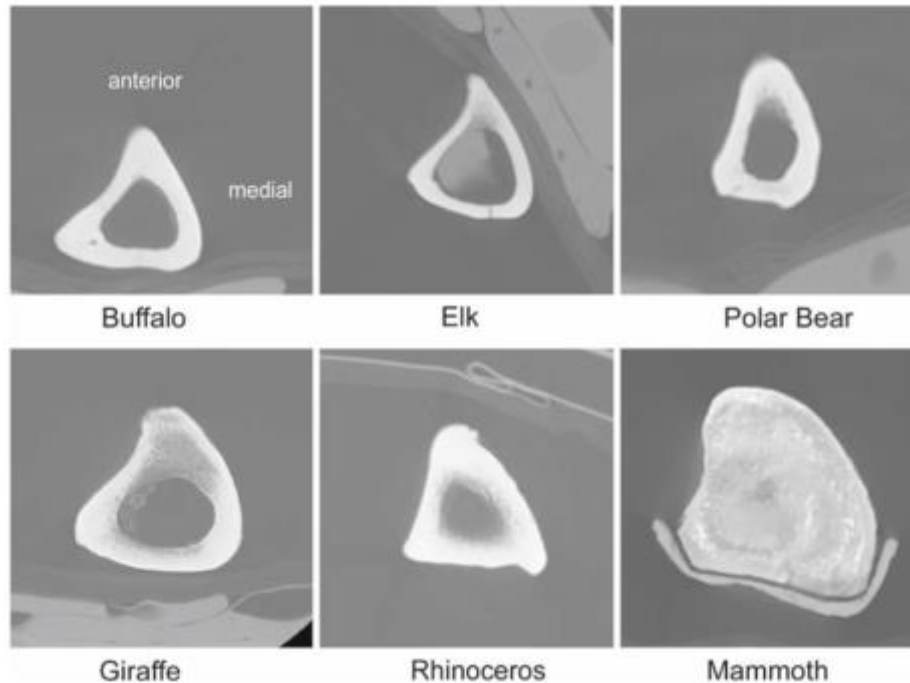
Cross-sectional CT scans of the tibiae of six terrestrial mammals, showing the roughly triangular shaft shape common to all, as taken from Carpenter and Carter (2008: 228).
